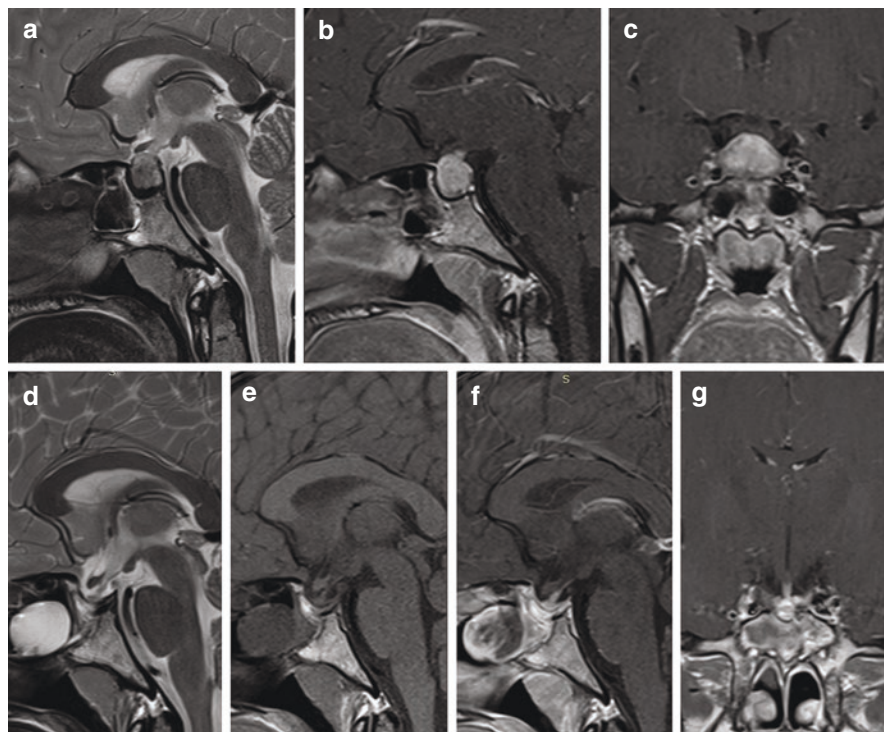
Sarcoidosis of the pituitary gland. Pre- (a–c) and postoperative (d–g) MR images after endoscopic endonasal transsphenoidal resection of the lesion
